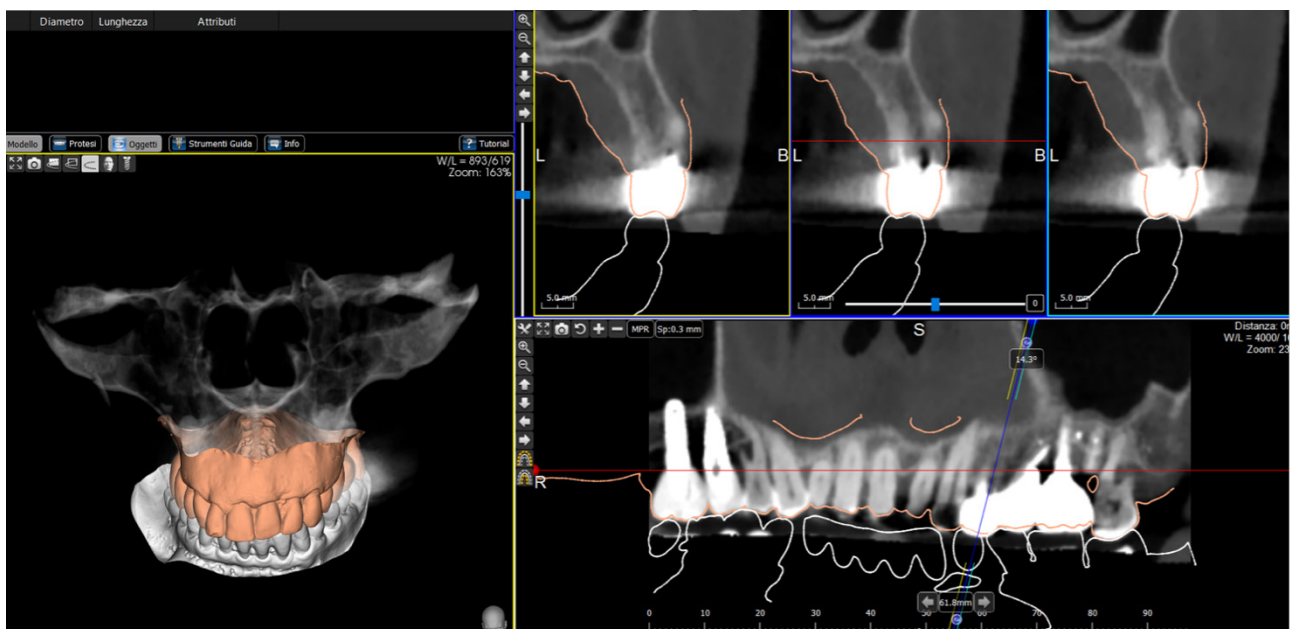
Overlay of DICOM images from CBCT to the scan of the patient's articulated model.
